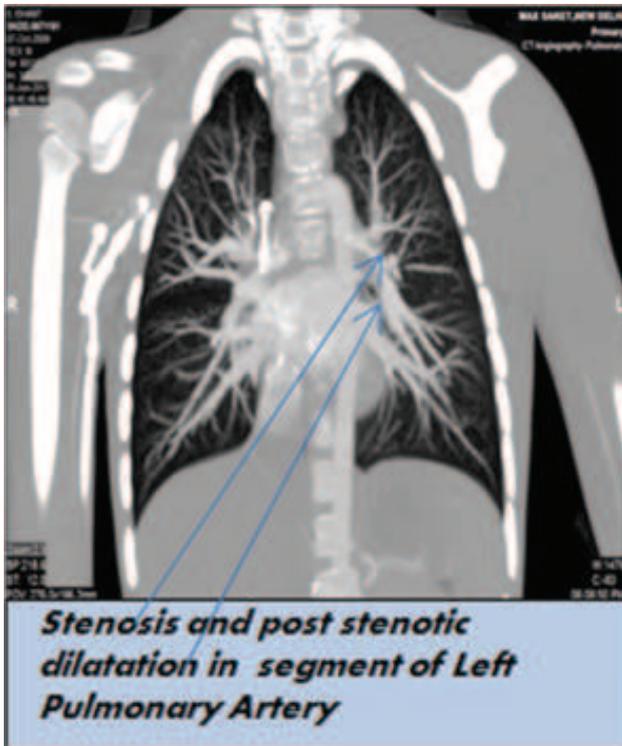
Showing CT angiography of the patient.
